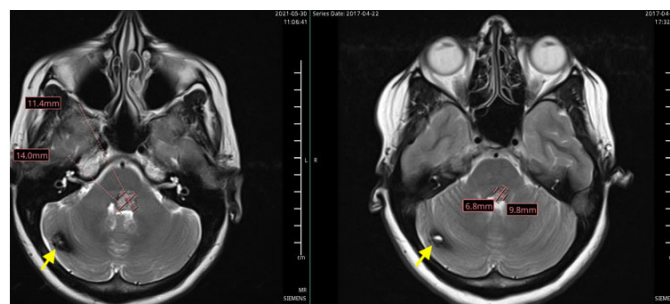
MRI T2-weighted axial sections comparing the increase in size of the cavernoma, located in the posterior aspect of the left paramedian posterior pons in 2017 and 2021 (yellow arrows).
